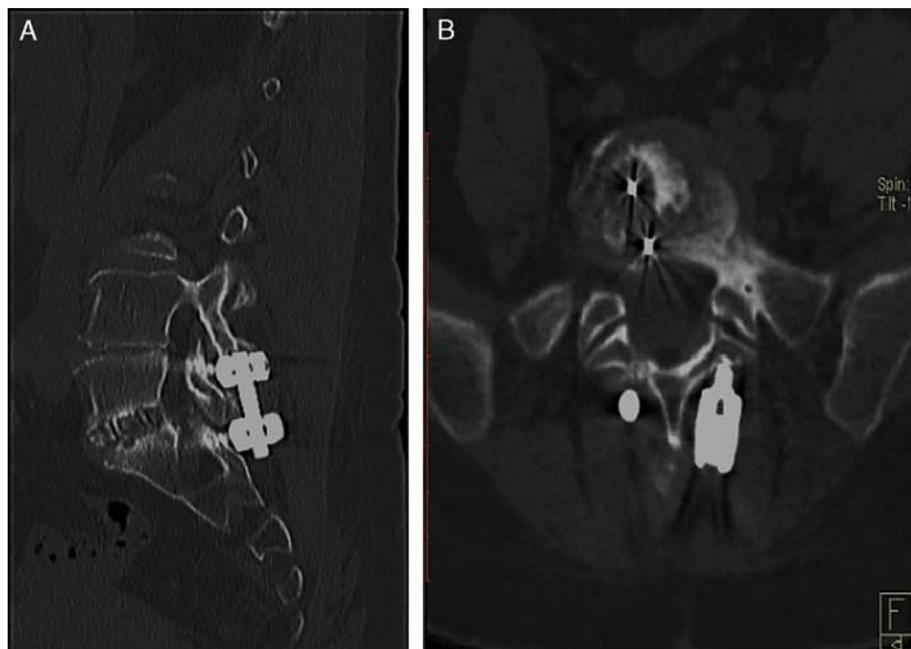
A, Postoperative sagittal computed tomography demonstrating fusion. B, Postoperative axial computed tomography demonstrating fusion. full color online
